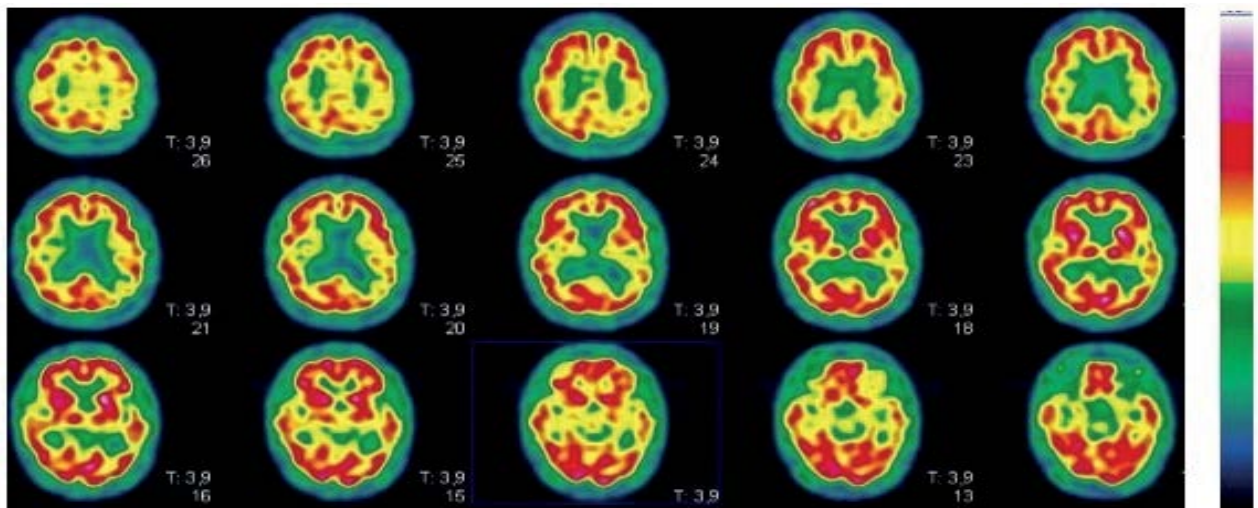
Brain Perfusion SPECT showing hypo perfusion with thinning of the right parietal association cortex.
